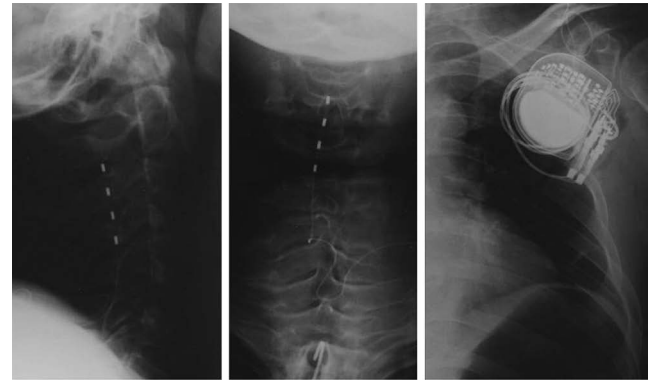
Cervical spinal cord stimulation. Radiography images showing the location of the stimulation electrode and implantable pulse generator (IPG). Left: lateral view, center: anteroposterior view, right: IPG under the anterior chest wall.
